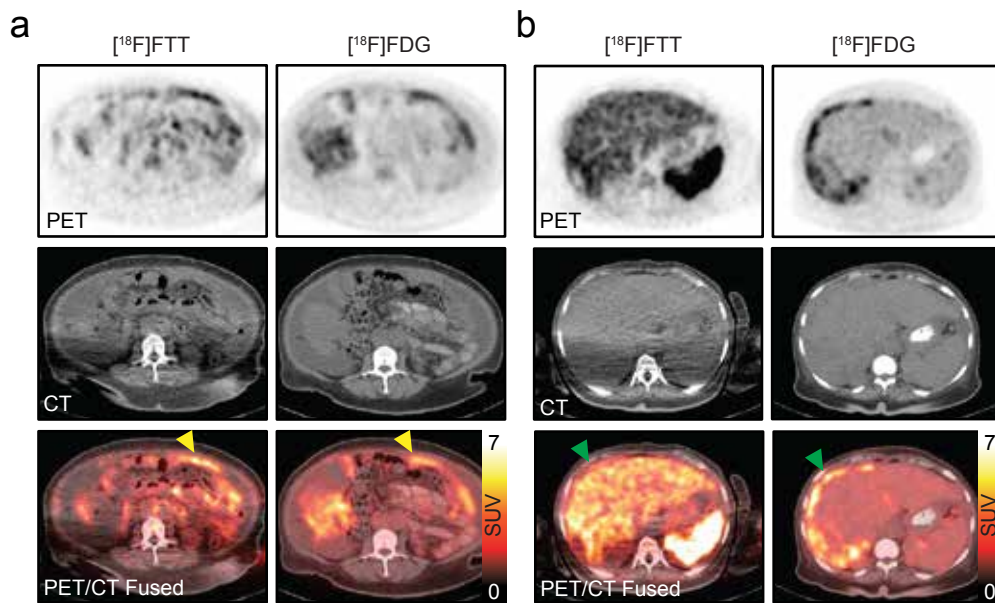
Figure s6: Heterogeneity of [^{18}F]FTT uptake between lesions in the same patient: PET images demonstrate omental disease in the left abdomen which demonstrates uptake on both [^{18}F]FTT and [^{18}F]FDG (yellow arrows: [^{18}F]FTT $\text{SUV}_{\text{MAX}} = 6.9$, [^{18}F]FDG $\text{SUV}_{\text{MAX}} = 5.4$). Carcinomatous hepatic implants demonstrate uptake on [^{18}F]FDG (green arrow: [^{18}F]FDG $\text{SUV}_{\text{MAX}} = 6.7$), but on [^{18}F]FTT demonstrate uptake less than that of liver (mean liver $\text{SUV} = 4.4$). This patient was in the dosimetry cohort; the above [^{18}F]FTT images were obtained at approximately 2 hours after radiotracer injection.
